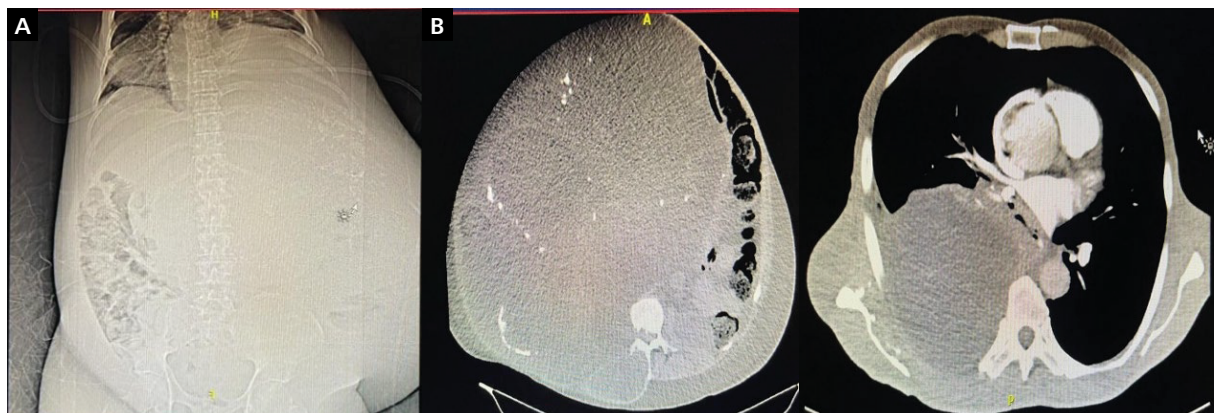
Radiograph (Rx) simple abdomen shows extensive abdominal occupation by tumor mass and displacement of other structures (A); computed tomography (CT) angiography of the chest and abdomen shows pleural and pericardial tumor involvement and associated right pleural effusion (B)
